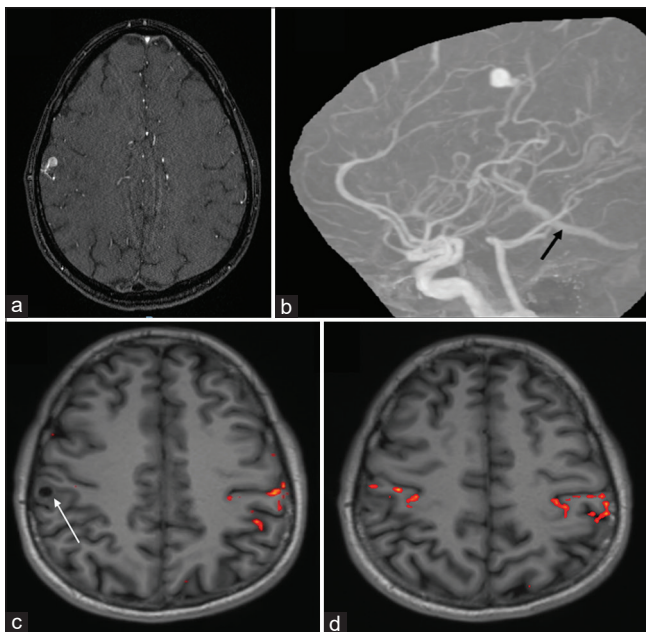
(a) Magnetic resonance imaging (axial view) demonstrating a small (about 2 cm) arteriovenous malformations located in the right precentral cortical location on the dorsolateral aspect. (b) Magnetic resonance angiogram (lateral view) showed that the arteriovenous malformations was being supplied by distal M4 branches with the venous varix draining into the vein of Labbe through an intermediate vein (black arrow) and subsequently into the right transverse sinus. No evidence of deep venous drainage was observed. (c and d) Functional magnetic resonance imaging axial views showing the eloquence of perilesional brain parenchyma
